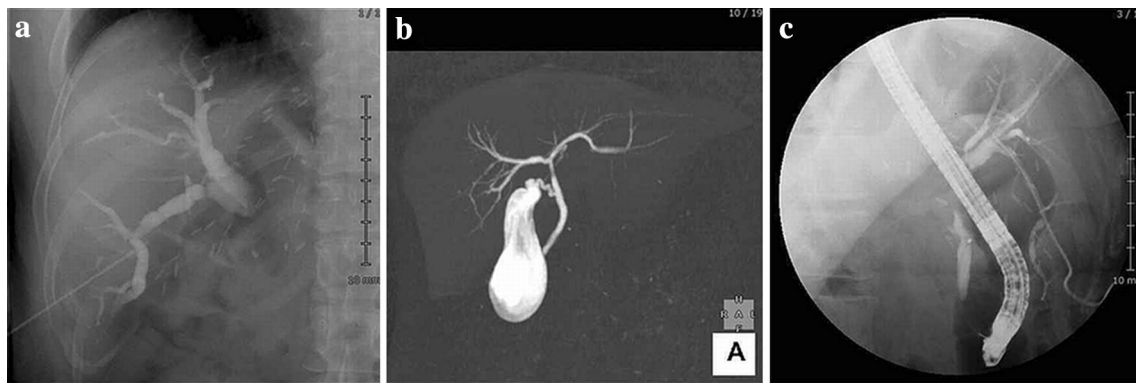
a Percutaneous transhepatic cholangiography showed dilation of the intrahepatic bile duct. b The donor's preoperative computed tomography combined with drip infusion cholangiography revealed
